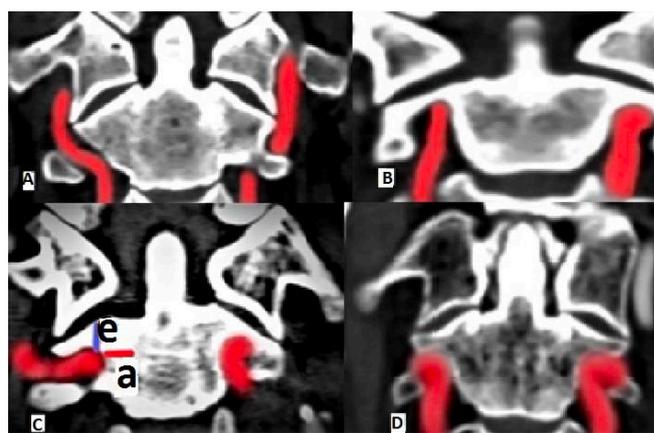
Arteria vertebralis are coloured in 3D-CTA coronal section images. A) Bilateral Type I pedicle, male case. Right pedicle; e:8.32mm, a:8.15mm. Left pedicle e:8.51mm, a: 6.59mm B) Bilateral Type II pedicle, female patient. Right pedicle; e: 1.91mm, a: 0mm. Left pedicle e: 3.43mm, a: 3.92mm C) Bilateral Type III pedicle male case. Representative e and a parameters are shown. Right pedicle; e:5.86mm, a:3.7mm. Left pedicle e:5.55mm, a: 3.1mm D) Bilateral Type IV pedicle male case. Right pedicle; e:3.8mm, a: 6.11mm. Left pedicle e: 3.8mm, a:4.79mm.
